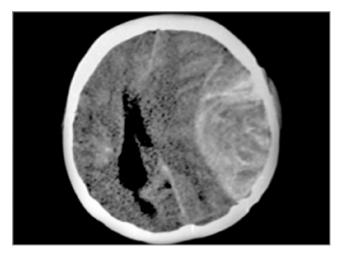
Plain CT head showing hyperdense shadow which biconvex in appearance suggestive of acute left extradural hematoma.
